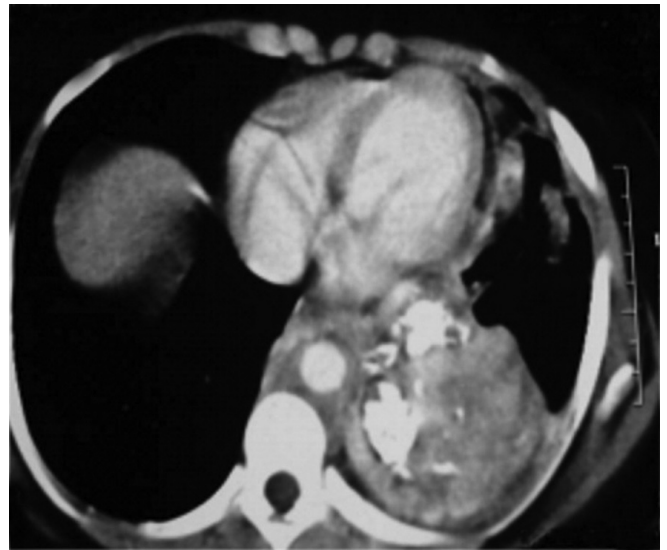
Chest CT: heterogeneous mass at left lower lobe basal posterior part.
